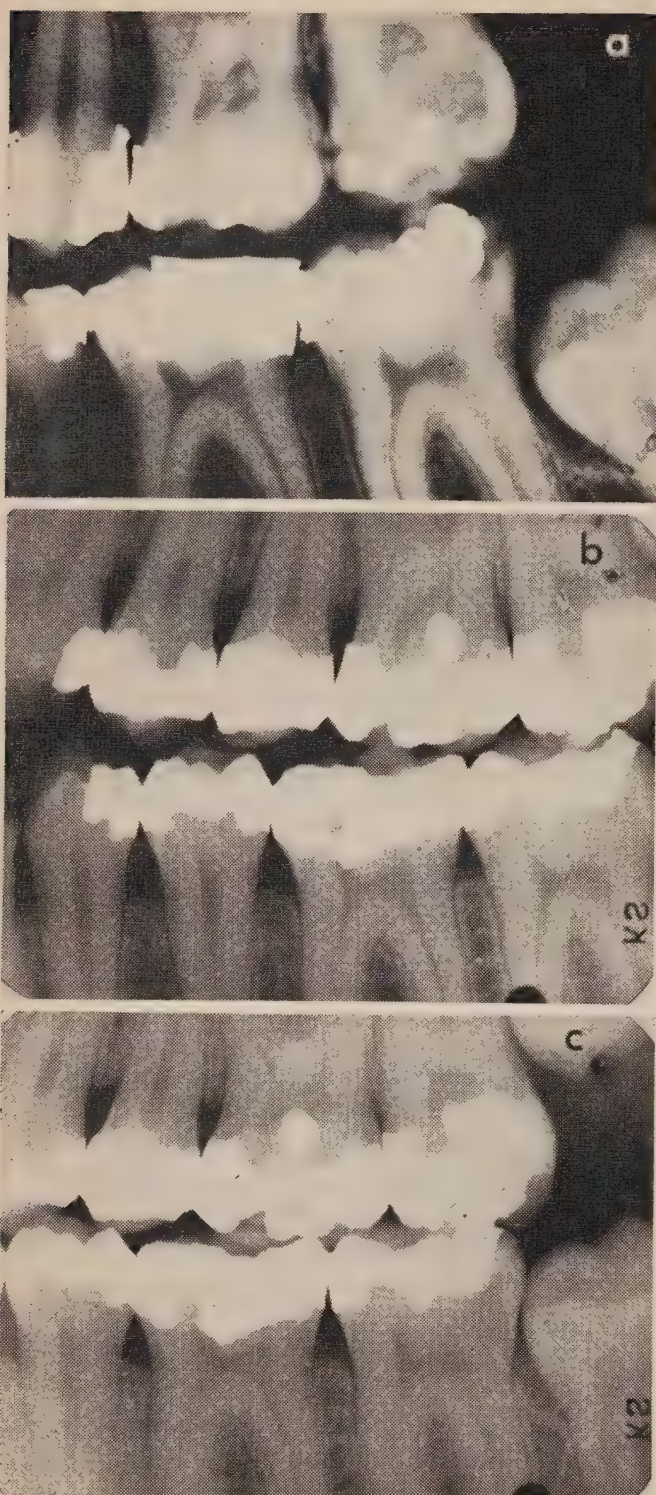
(a) Bitewing radiograph with evidence of carious lesions and restorations with marginal excesses. (b, c) Bitewing radiographs following treatment.
